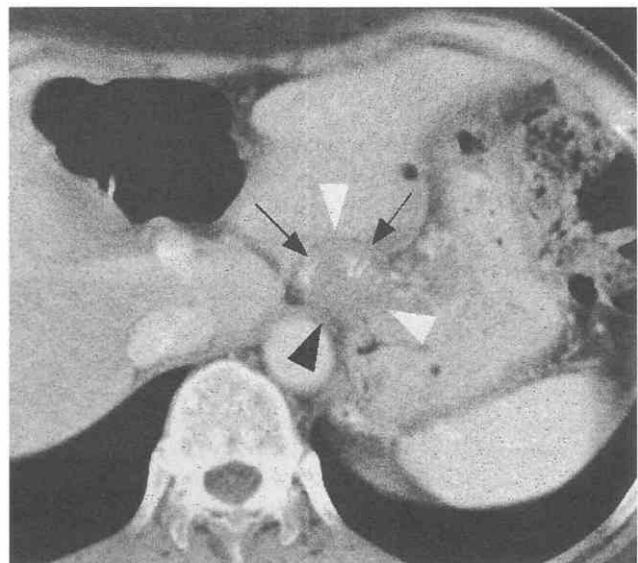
Calcified leiomyoma of the esophagus. CT scan demonstrates concentric wall thickening (arrowheads) of the gastroesophageal junction. This lesion contains multifocal calcifications (arrows).
